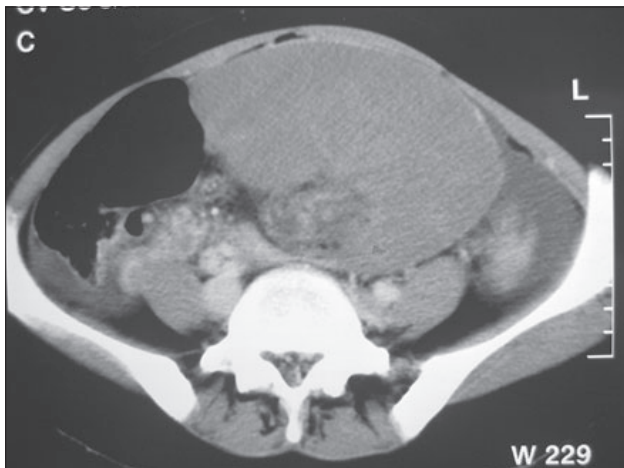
Contrast enhanced CT scan of the abdomen shows a mass of 20x13x7 cm in diameter with smooth contour and hypodense infarcted areas within it.
